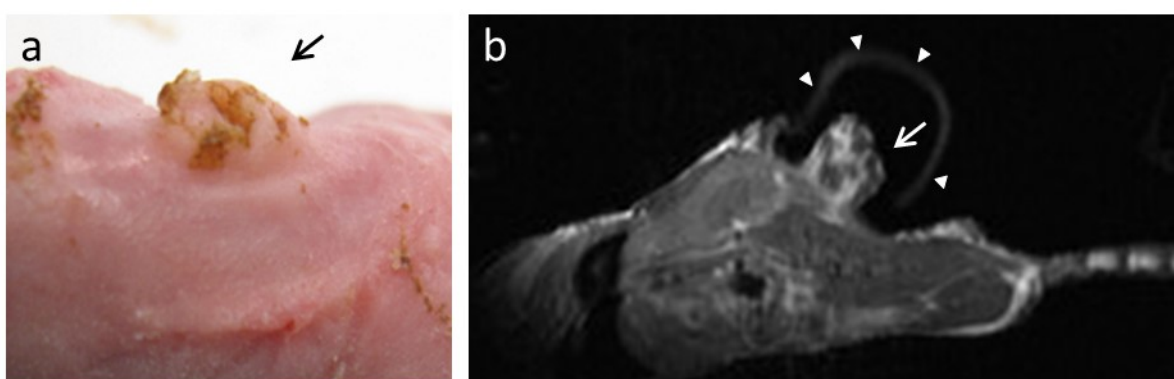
Tissue expansion induced by EVE (a) macroscopically evident at EVE removal (b) during EVE at MRI
